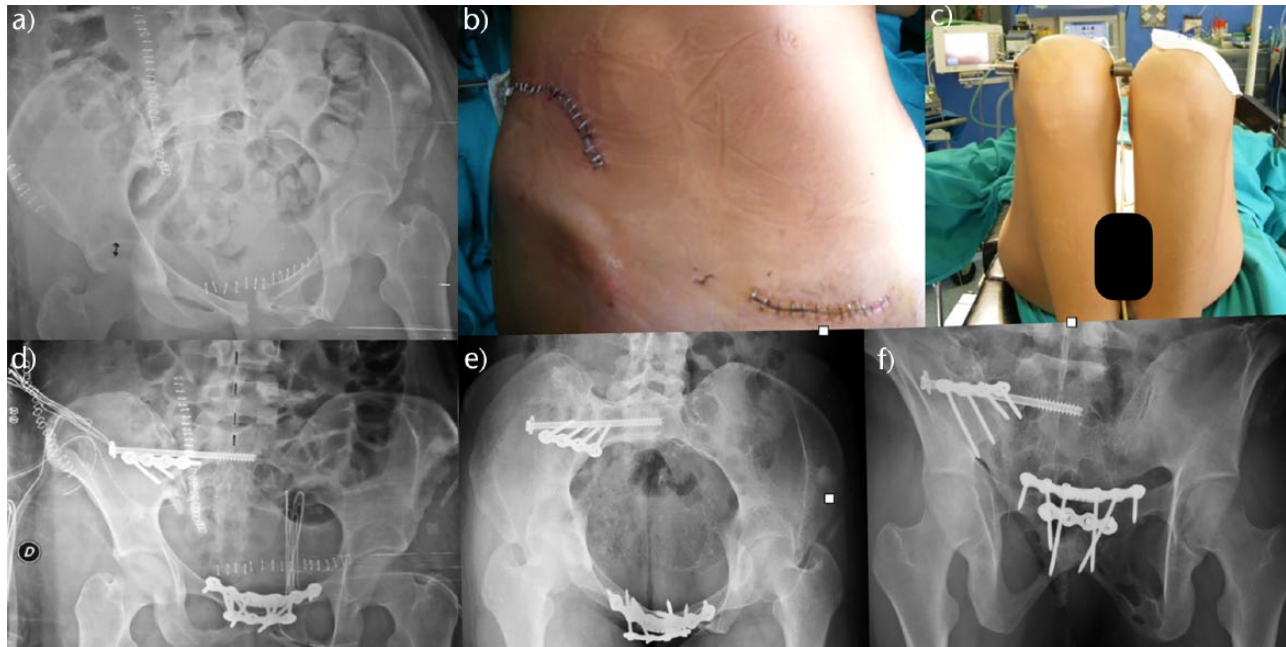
Type IB complex instability with leg-length discrepancy > 3 cm postoperative (case of Fig. 3): a) radiograph after first and second stage (sequential liberation surgery and correction of the deformity); b) clinical photograph showing pelvic descent; c) leg-length discrepancy restoration; d) postoperative radiograph; e) and f) inlet and outlet radiograph views after nine years of follow-up.
